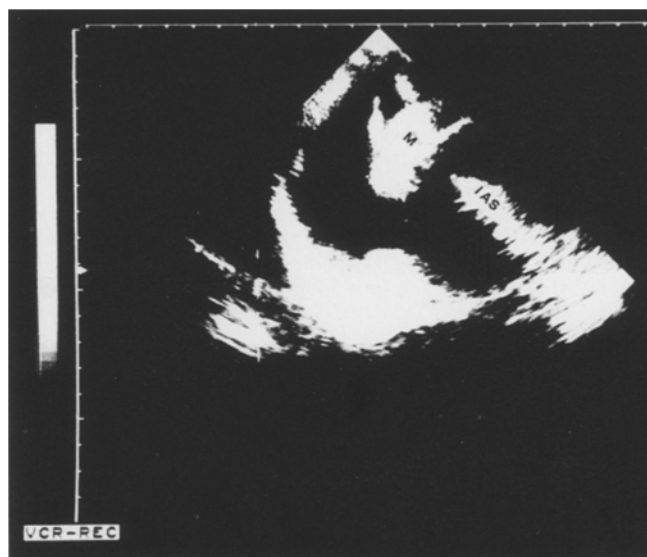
Transoesophageal echocardiogram. A mass (M) is attached to the lower portion of the interatrial septum (IAS) and is bulging into the right atrium
